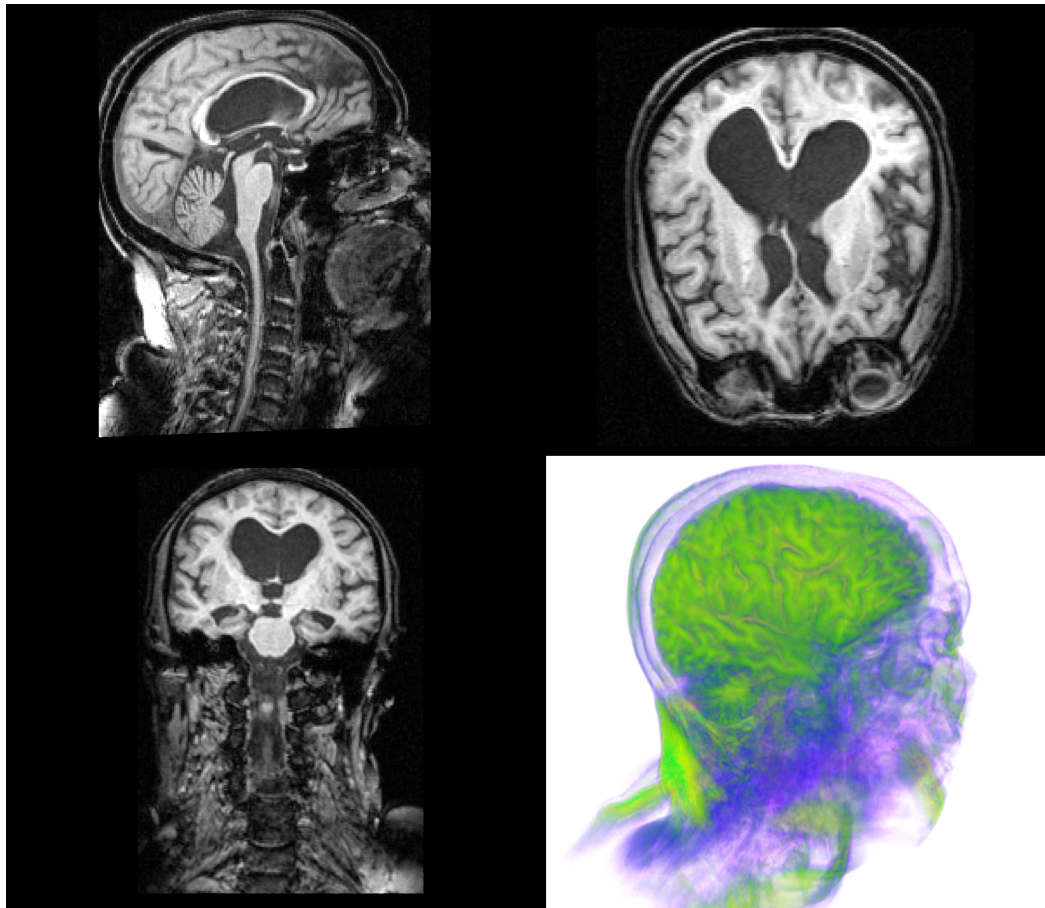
Sagittal and Coronal MRI slices of a hydrocephalic brain from the patient described in Case 2 of §5.2.1.1. This patient suffered from chronic hydrocephalus with no observable blockage to the CSF flow path; the enlarged lateral ventricles are easily observed, yet it is important to notice the enlarged CSF flow path (aqueduct, third and fourth ventricles) that would be absent if a flow obstruction was present in the cerebral aqueduct. It is also possible to see compression and distortion of other areas of the brain such as the cerebellum and white matter.
